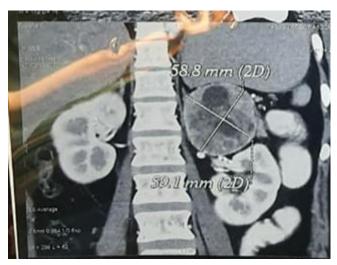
CT scan showing Left Adrenal Mass 58.8 x 59.1 mm
